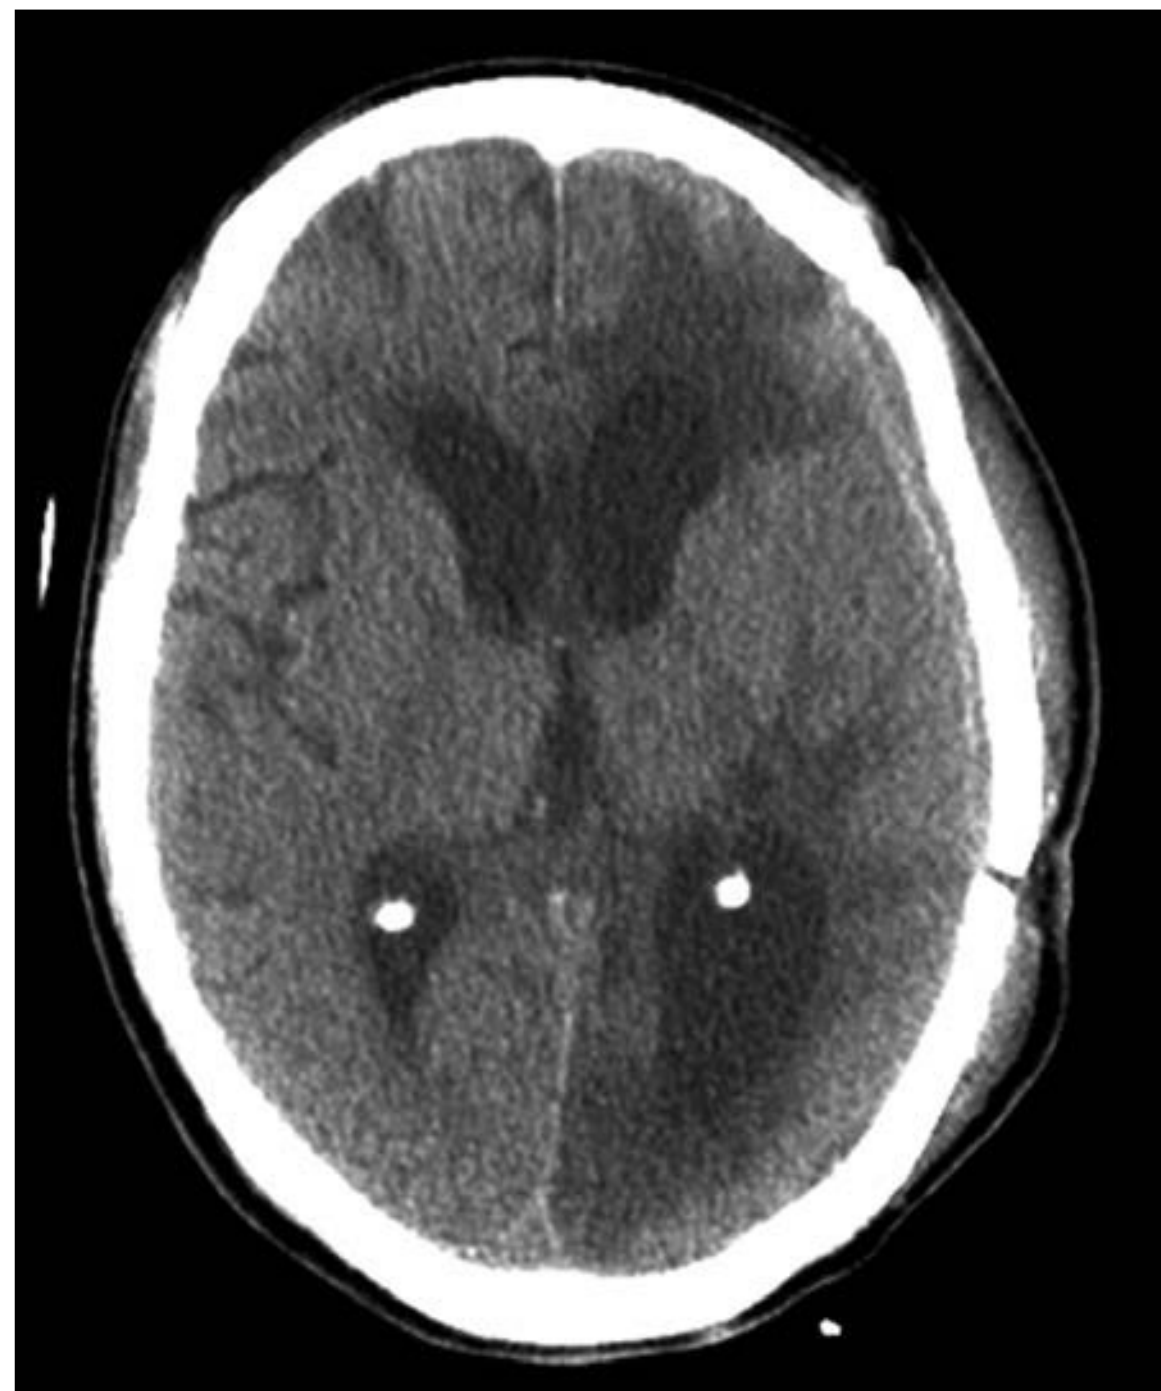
Computed tomography head scan after bone flap replacement.
